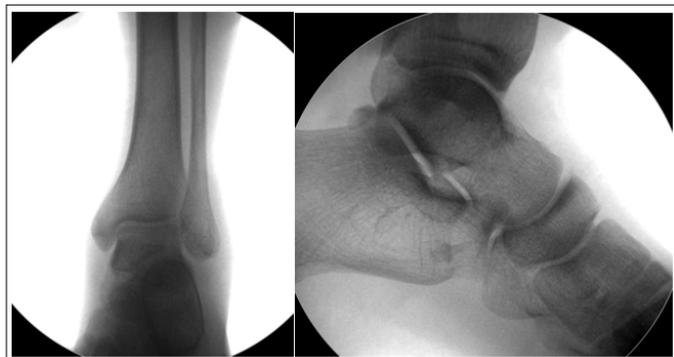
AP and Lateral Radiography after Reduction
